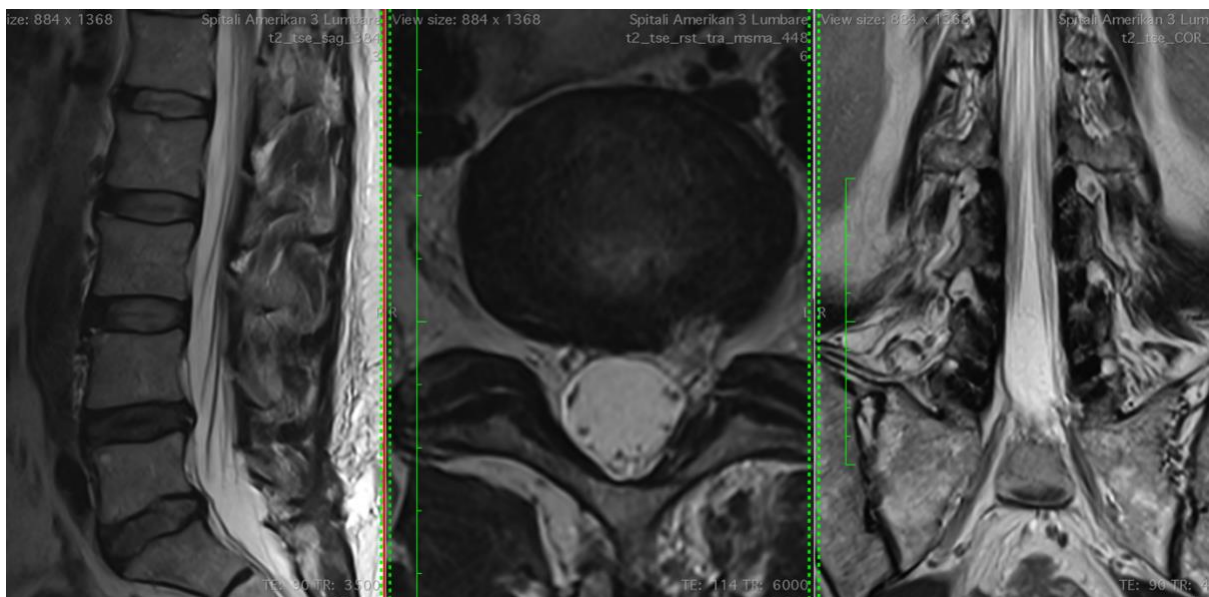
Postoperative MRI: complete resection of the cystic lesion*
